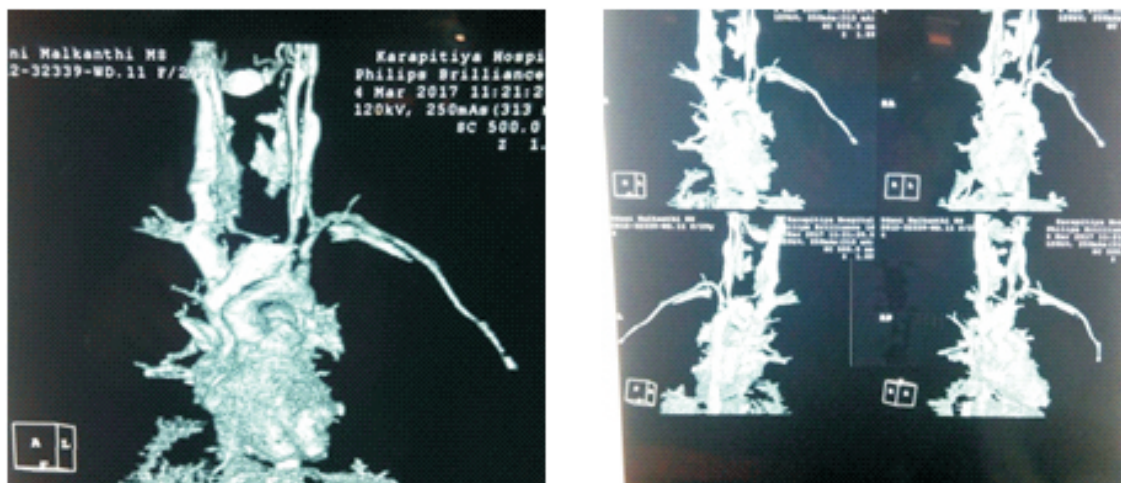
CT angiogram showing abrupt cut off right subclavian artery with thrombosis
